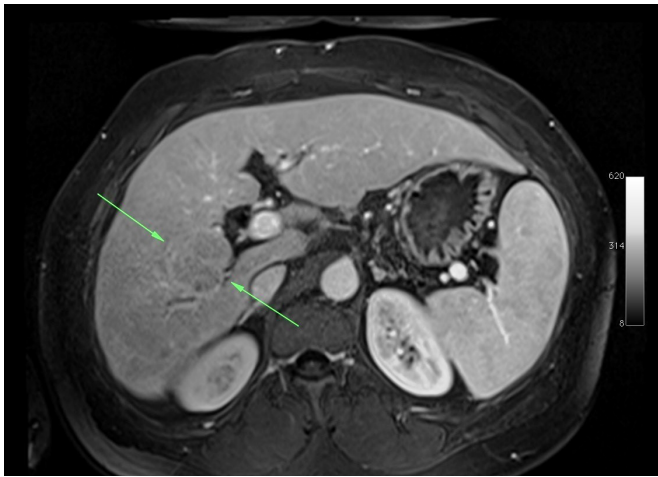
Liver MRI – T1 with injection, portal phase. Hepatocarcinoma (arrows)
